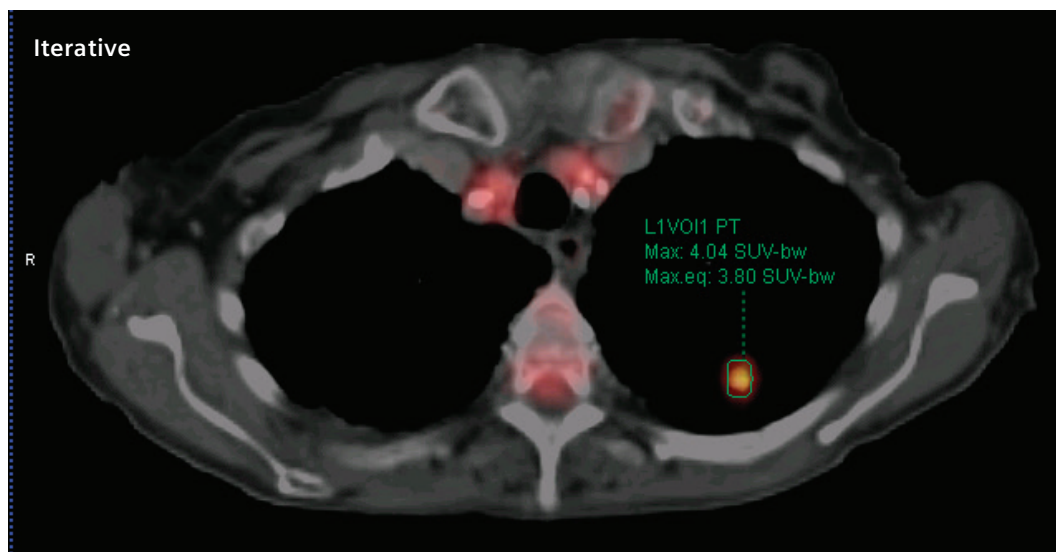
Lung cancer patient reconstructed with Iterative, HD•PET, and UltraHD•PET. The SUV_{max} for a small lesion in the posterior left lung increases with the addition of advanced reconstruction techniques.
